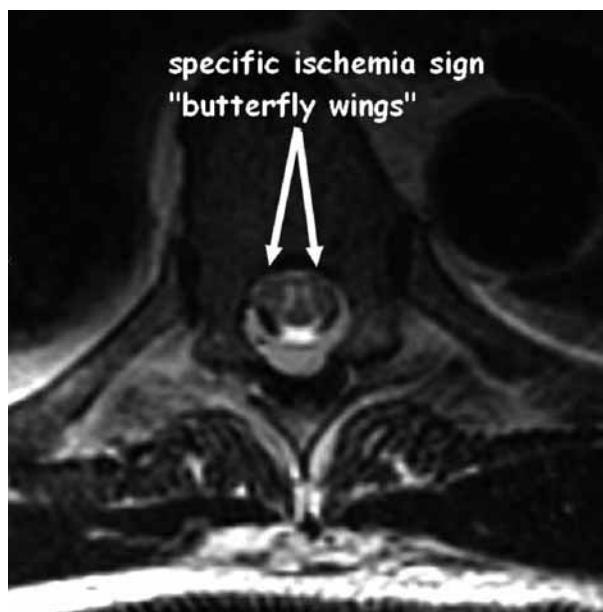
Magnetic resonance image (axial cross-sectional view T2-weighted image) at the level of T10 showing the specific spinal ischemia sign "butterfly wings".
